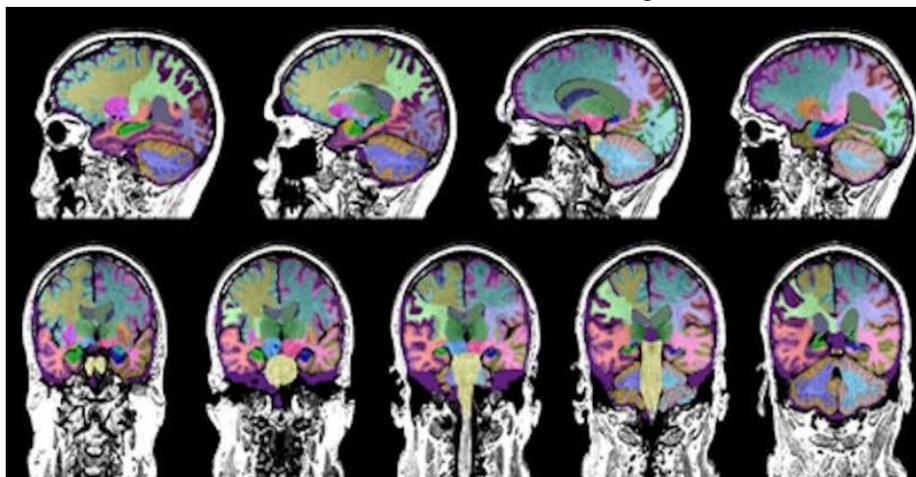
MRI report of brain shrinkage in Alzheimer Disease timely (11, 12).
